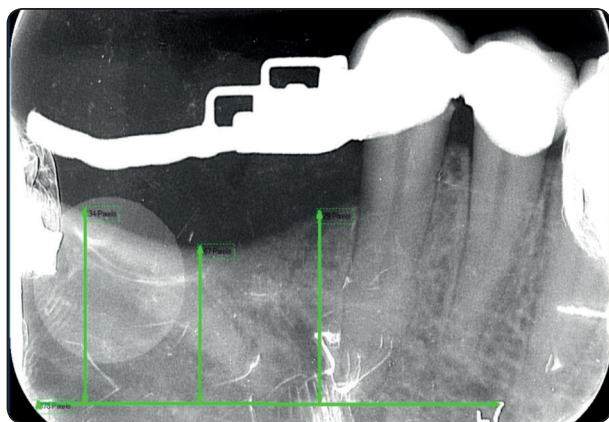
Digital radiography measuring marginal bone height change
